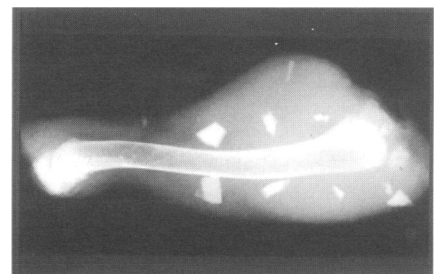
Radiograph of a chicken drumstick taken at 45 mV showing glass and china fragments.
